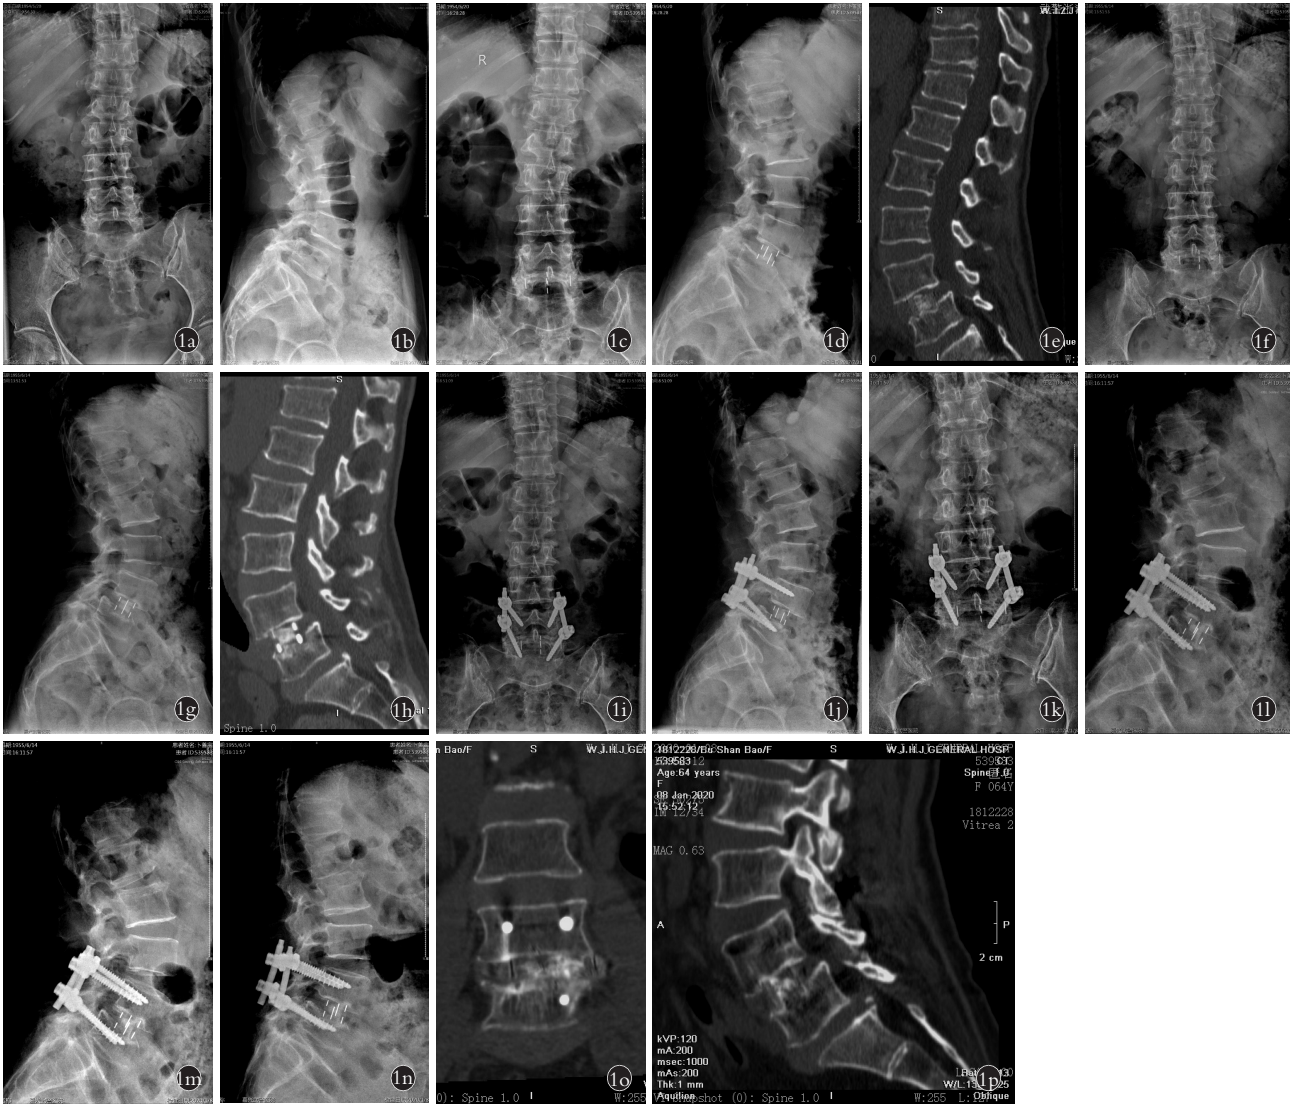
患者,女,63岁,L₄退行性滑脱症 I 度 1a,1b. 术前腰椎正侧位 X 线片示 L₄ 椎体向前滑移 I 度,L_{4,5} 椎间隙高度下降 1c,1d. 经斜外侧入路 L_{4,5} 椎间融合器植骨术后 3 d 腰椎正侧位 X 线片示 L₄ 椎体仍轻度向前滑移,L_{4,5} 椎间隙高度恢复良好,融合器在位 1e. 术后 3 d 腰椎 CT 平扫并矢状面重建示 L₅ 上终板损伤,L_{4,5} 椎间隙高度恢复良好,融合器在位 1f,1g. 术后 2 个月腰椎正侧位 X 线片示 L_{4,5} 椎间隙高度明显丢失,融合器向左侧横向移位 1h. 术后 2 个月腰椎 CT 平扫并矢状面重建示 L_{4,5} 椎间隙高度明显丢失,融合器切割 L₅ 上终板,部分嵌入 L₅ 椎体 1i,1j. 第 1 次术后 2 个月行后方肌间隙入路通道下 L_{4,5} 椎弓根螺钉固定术,再次手术后 3 d 腰椎正侧位 X 线片示 L_{4,5} 椎弓根螺钉及椎间融合器在位 1k,1l. 再次手术后 2 年腰椎正侧位 X 线片示 L_{4,5} 椎间隙高度获得较好维持,L_{4,5} 椎弓根螺钉在位,椎间融合器无进一步移位 1m,1n. 再次手术后 2 年腰椎过屈过伸侧位 X 线片示 L₄ 下终板和 L₅ 上终板角度无明显变化,L₄、L₅ 椎体无相对移位 1o,1p. 再次手术后 2 年腰椎 CT 平扫加冠状面、矢状面重建示 L_{4,5} 椎间融合较好
